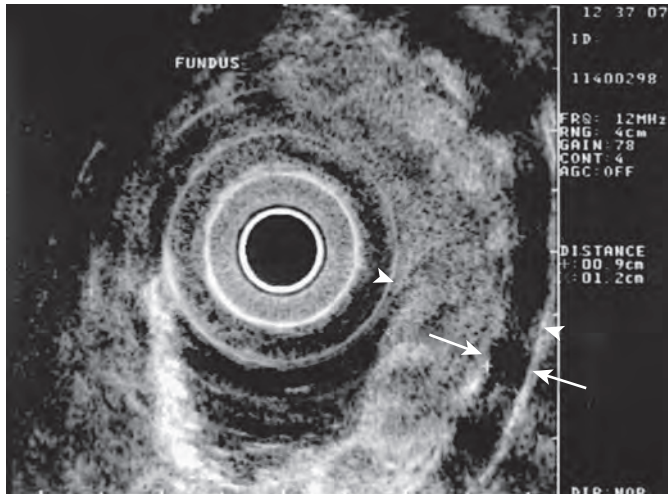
Endoscopic ultrasound appearance of linitis plastica. There is marked thickening of the entire gastric wall (arrowheads) with associated thickening of the muscularis propria (arrows).
